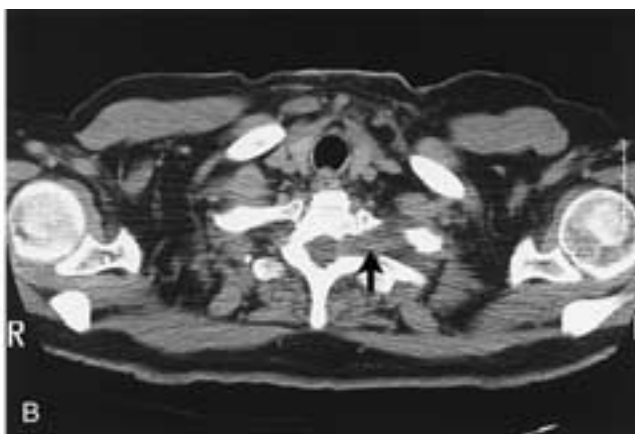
Neural tumor. Axial CT images obtained through the lung apex (*A*) and lower neck (*B*) show a well-circumscribed lesion in the left lung apex that extends into the neural foramen (*arrow*) in the lower neck. Coronal postgadolinium T1-weighted MR image (*C*) shows heterogeneous enhancement in the lesion (*arrow*). Note the smooth interface between the lesion and the lung.
